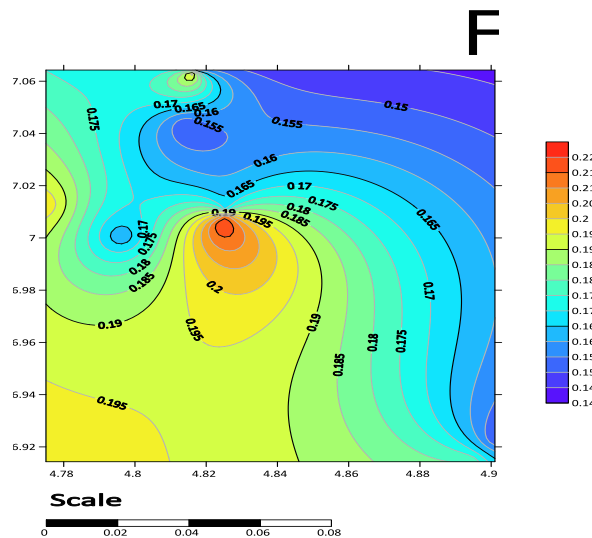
Contour map of background ionization radiation of the sampled X-ray diagnostics centers
